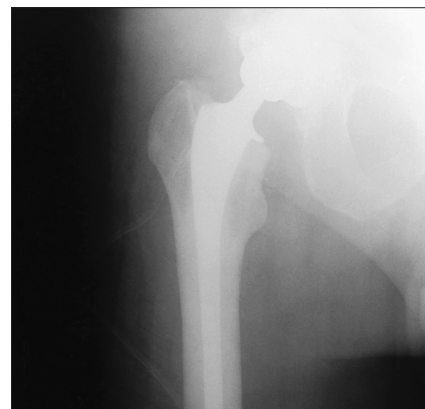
Postoperative radiograph of a right total hip joint replacement.
